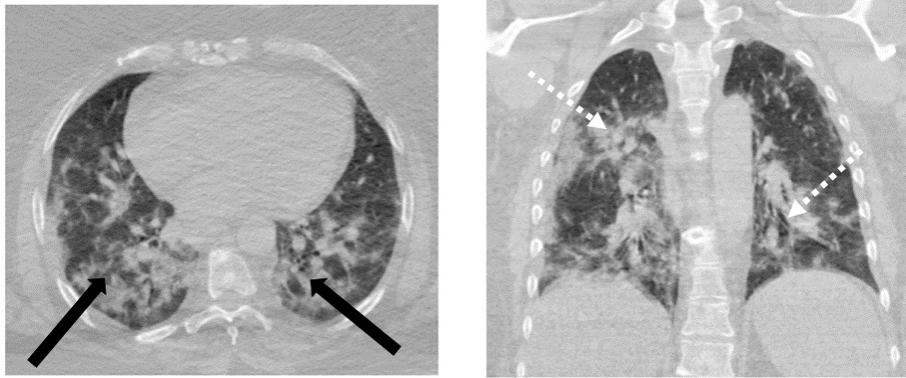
High resolution computed tomographic axial sections and coronal reconstruction images shows bilateral multilobar areas of bronchial wall thickening with cluster areas of ground glass opacities (black thick arrows). Peri-bronchial cuffing and interstitial septal thickening (white thin dashed arrows). There are areas of consolidation with air bronchogram in the basal and posterior lung aspects in both sides. There are areas of basal pleural thickening, however no pleural effusion. No lymphadenopathy.
